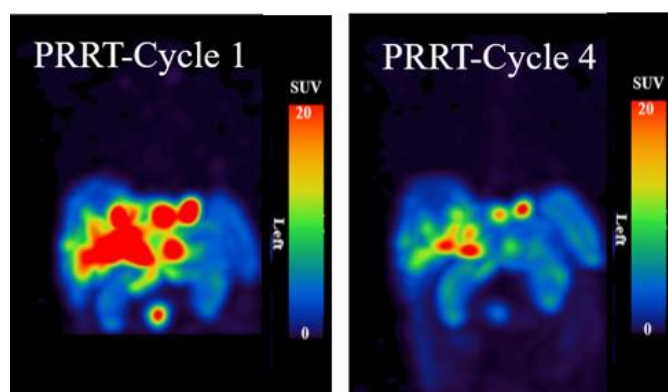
Maximum-intensity projection (MIP) SPECT/CT images 24-hour following administration of ^{177}Lu -DOTA-TATE at PRRT-cycles 1 and 4. Multiple NET lesions showed decreased somatostatin expression after four cycles of PRRT.
